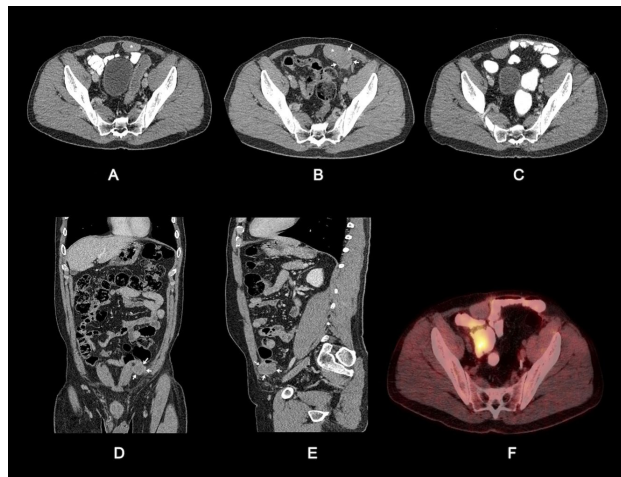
Contrast-enhanced axial CT image (A) in the preoperative period (October 2018). In multiplanar contrast-enhanced CT images (B, D, E) a solid lesion (arrows) with irregular border of soft tissue density that invades the left rectus abdominis muscle (asterisk) and where the planes in between are not visible. Postoperative period changes: axial CT (C) and PET-CT (F) (January 2021).
